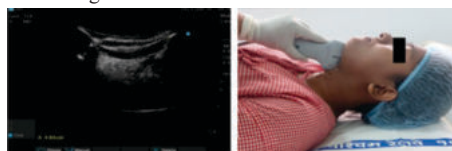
Ultrasound Measurement of HMD: Ultrasound Pprobe in Parasagittal Position
